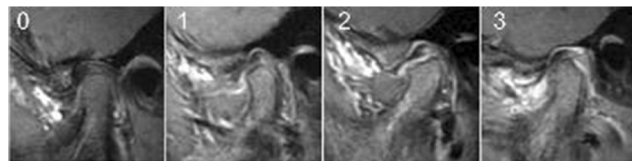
Figure A Contrast-enhanced T1-weighted images showing inflammatory grades 0-3 (normal, mild, moderate, severe)
